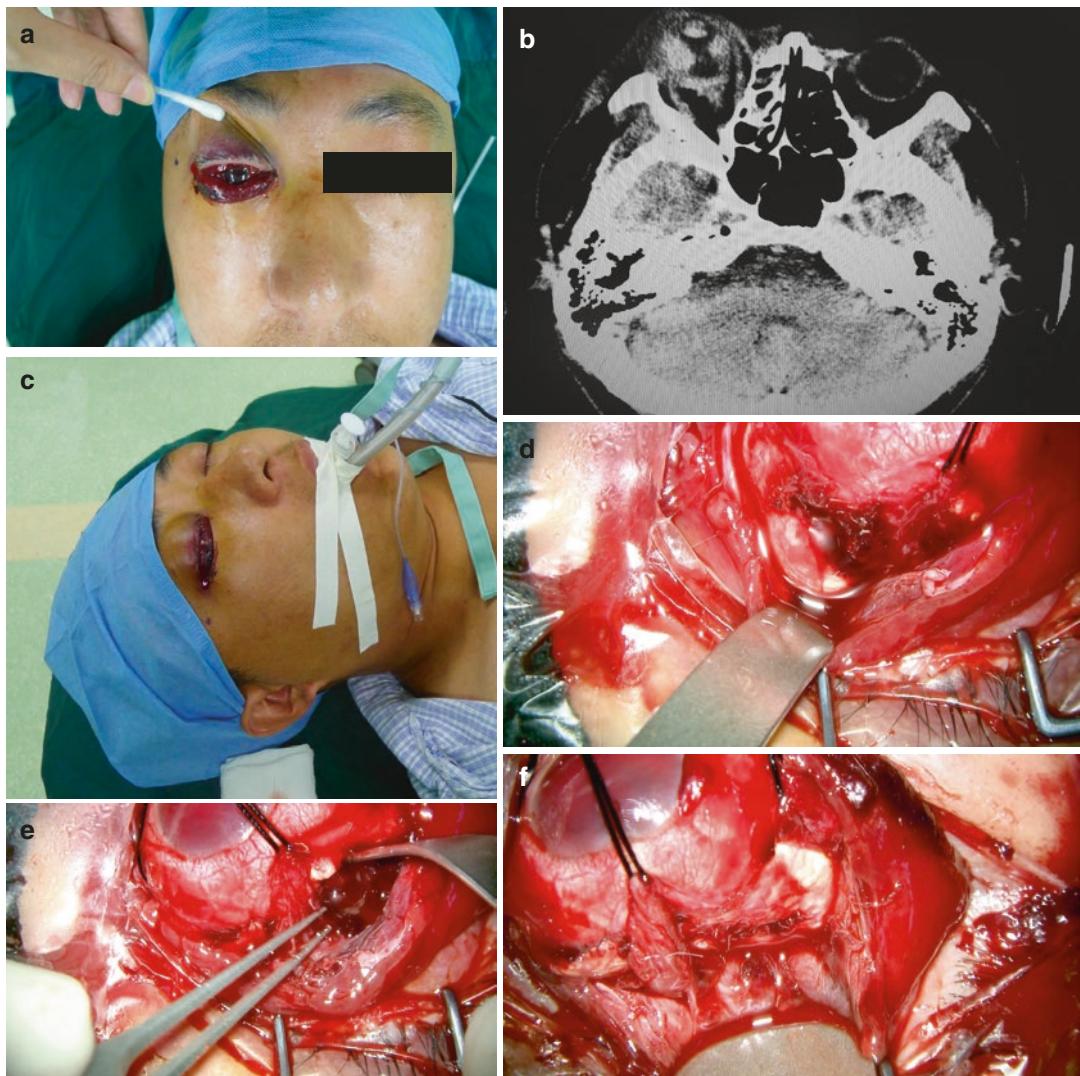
(a) A 33-year-old male, the right eyeball was injured by an elbow during exercise (12-7-24). (b) CT scan showing wall of globe was incomplete. (c) General anesthesia is recommended for open globe injury. (d) First phase repair (12-7-27): Globe exploration: 360° peritomy is made, and Tenon's capsule is retracted posteriorly to reveal the underlying sclera; nasal of superior rectus is exposed. (e) Temporal of superior rectus is exposed, and rupture of sclera with protrusion of choroid and retinal tissue is shown. (f) Watertight suture using interrupted 8-0 absorbable thread. Prolapsed uveal or retinal tissue was
